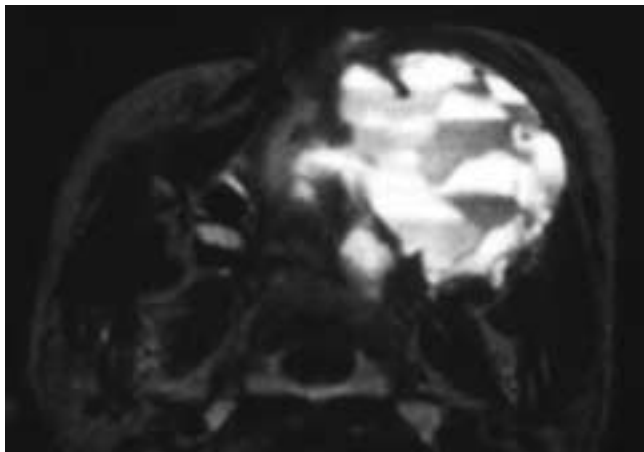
Axial T2-weighted MR image shows multiple cystic components with fluid-fluid levels within a left maxillary sinus mass. This patient had an aneurysmal bone cyst. (Courtesy of Dr. Revel and Dr. Vanel.)
